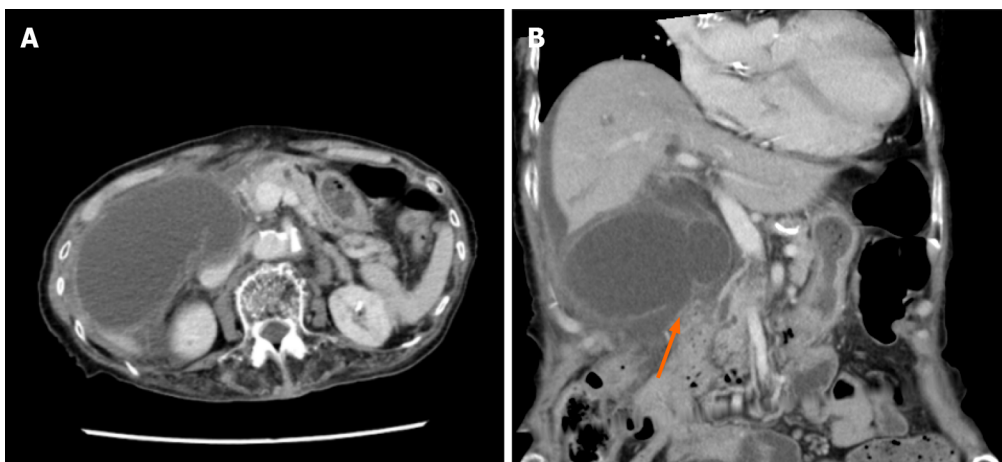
An abdominal contrast-enhanced computed tomography (Case 2). A: Significant swelling of the gallbladder. Ascites around the liver; B: There was asymmetrical gallbladder wall thickening and the continuity of part of the wall was ambiguous (arrow).
